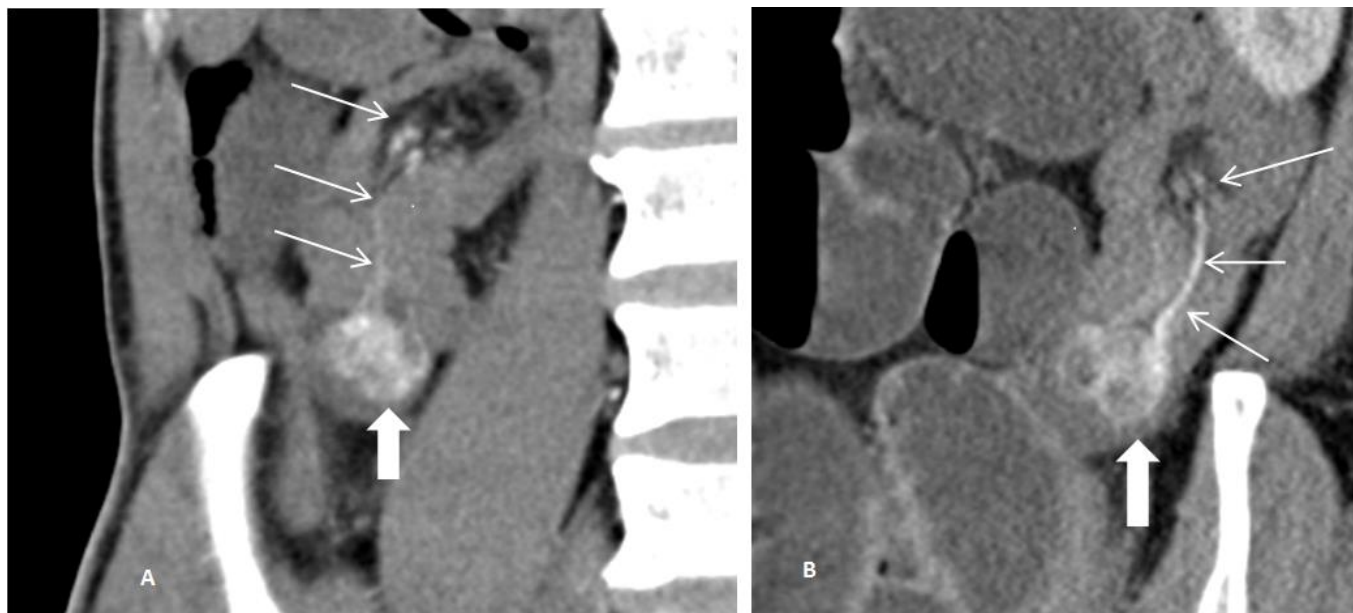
52 year old male patient with left renal cell carcinoma and a metastatic ileo-ileal intussusception. Coronal (A) and Sagittal (B) thick multiplanar reconstructions of the arterial phase (zoomed-in images) reveal the polypoidal mass at the lead point (thick white arrow) dragging with it the mesentery and a leash of mesenteric vessels (thin white arrows). TECHNIQUE: Coronal and Sagittal CT reconstructions, 105 mAs, 120 kV, 3 mm slice thickness, 80 ml iohexol.
